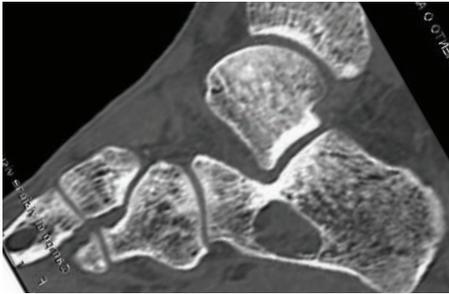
CT Scan of the initial situation.
